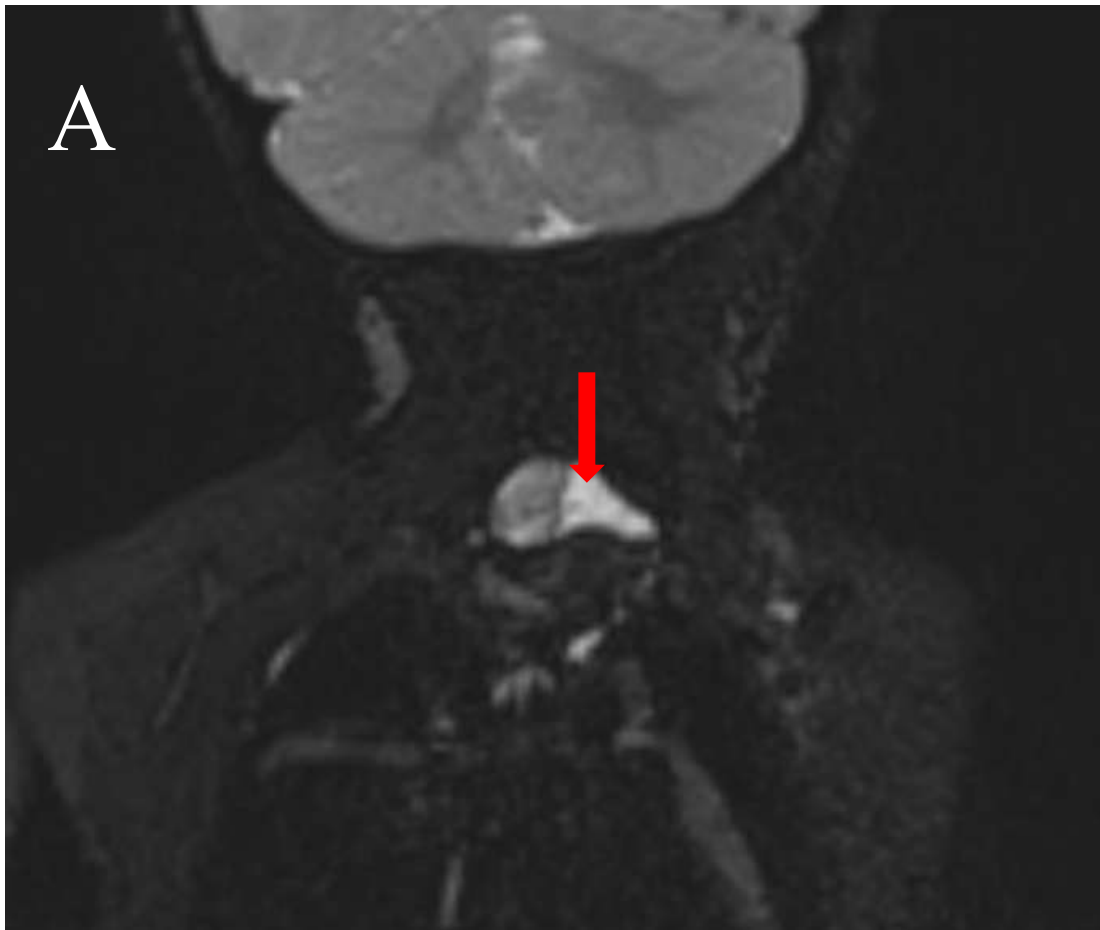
MRI images in coronal (A) and axial (B) sections of T2 3D SPACE showing foraminal and extraforminal cystic formation spoiled in hypersignal without individualization of the nerve roots (red arrow).
